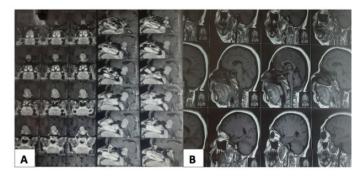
(A) Pre-operative and (B) post-operative MRI images of patient with non-functioning pituitary tumour operated via endoscopic transnasal transsphenoidal approach.
